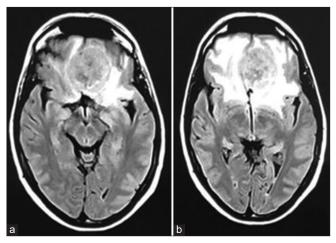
Axial view (a and b) of Fluid-attenuated inversion recovery (FLAIR) showing intense peritumoral brain edema.
